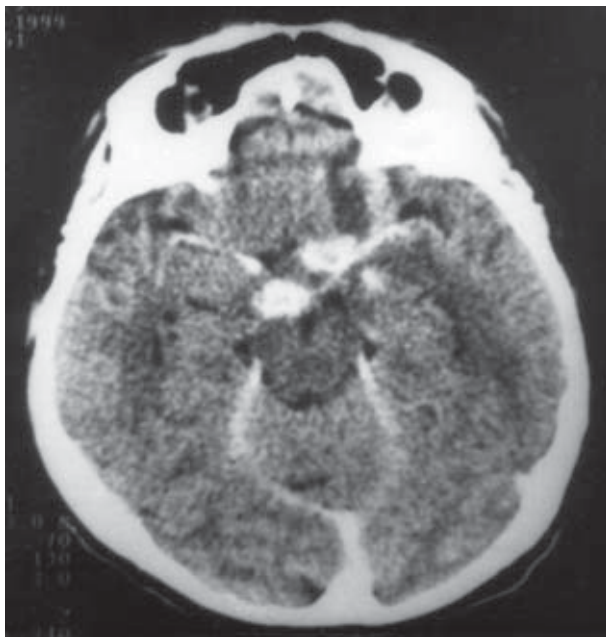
b) contrast enhanced CT with 'pseudo-aneurysm' tuberculomas
